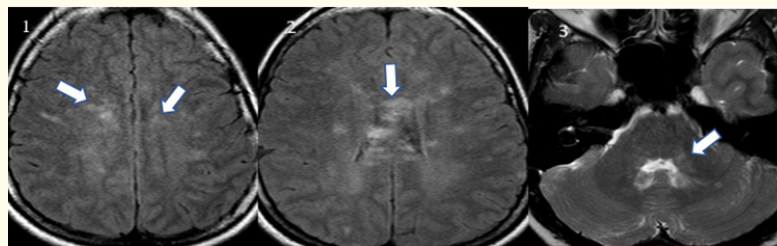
Axial FLAIR [1], [2] and T2W [3] images show multiple small, hyperintense lesions in the deep white matter, corpus callosum, cerebellum and middle cerebellar peduncles.
